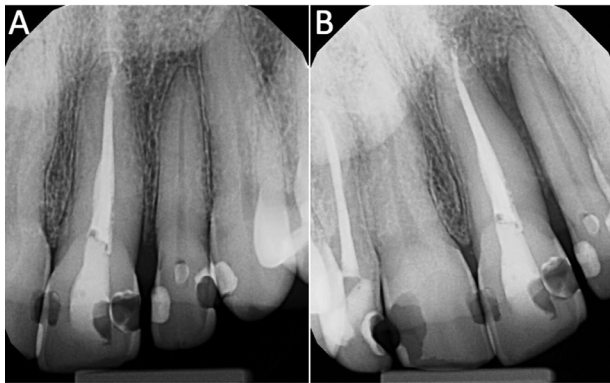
(A) Baseline periapical image shows intact laminae durae and periodontal ligament spaces. (B) One-year follow-up intraoral radiograph shows an area of ill-defined bone loss around teeth 9 and 10. Note the loss of lamina dura between the 2 teeth.
